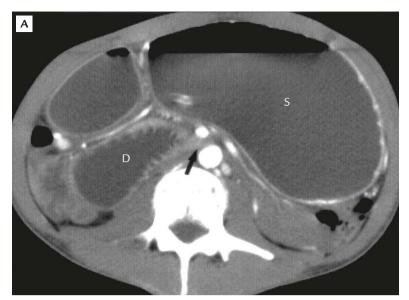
(A) Axial computed tomography and (B) reformatted coronal images of the abdomen reveal marked distension of the stomach (S) and dilatation of the second portion of the duodenum (D). The abruptly narrowed third portion of the duodenum (black arrow) is compressed between the superior mesenteric artery and abdominal aorta.
